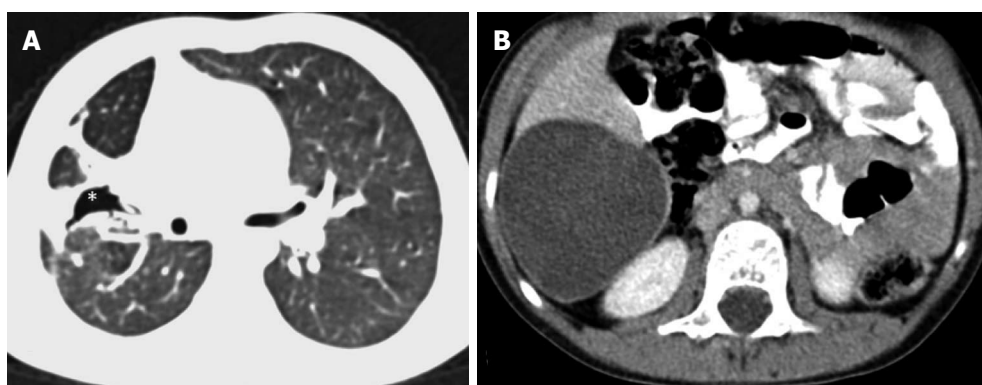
A seven-year-old girl with ruptured pulmonary hydatid cyst. Axial computed tomography image (A) showing the ruptured cyst with air (asterisk) in the right upper lobe along with surrounding consolidation. Axial section of the abdomen (B) shows an unruptured cyst in the segment VI of the liver.
